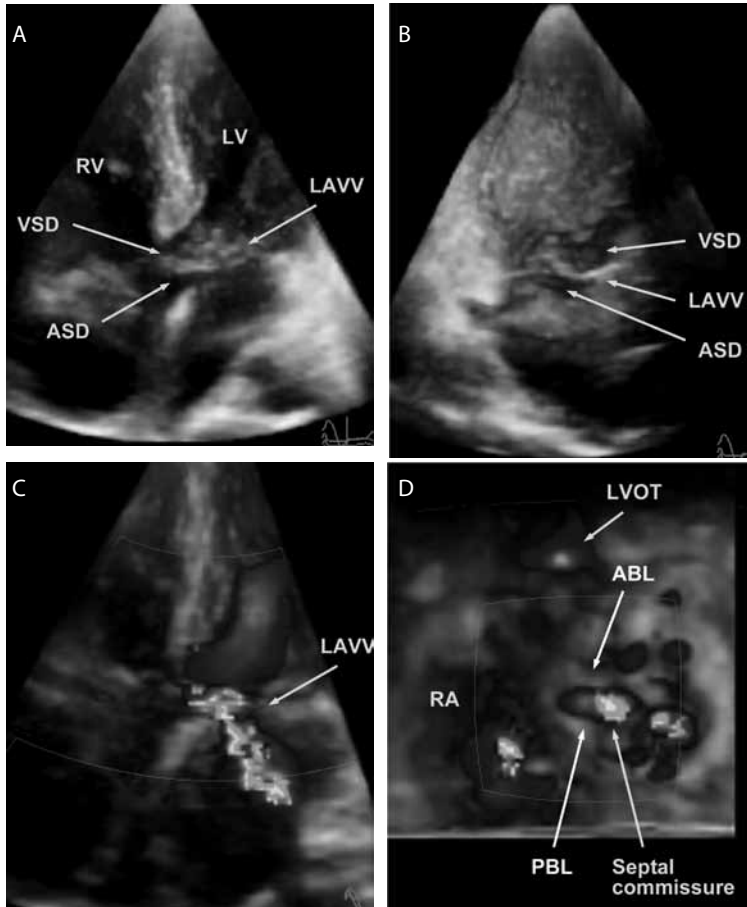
Example of a complete AVSD in a 46-year-old woman. The septal commissure, often (but actually erroneously) referred to as “cleft” in the left atrioventricular valve (LAVV) is indicated with an arrow. Top right The 3D en face view from left ventricle (LV) to the interventricular septum (IVS) shows clearly the atrial side of the AVSD below the LAVV and the ventricular side of the AVSD above the LAVV. Bottom left The 3D color Doppler 4-chamber view shows the regurgitant jet through the septal commissure in a typical location. Bottom right The 3D color Doppler short-axis en face view from the apex to the base shows the LAVV with a posterior bridging leaflet (PBL), an anterior bridging leaflet (ABL) and a septal commissure pointing to the ventricular septum. RV right ventricle, RA right atrium, ASD atrial septal defect, VSD ventricular septal defect, LVOT left ventricular outflow tract.
